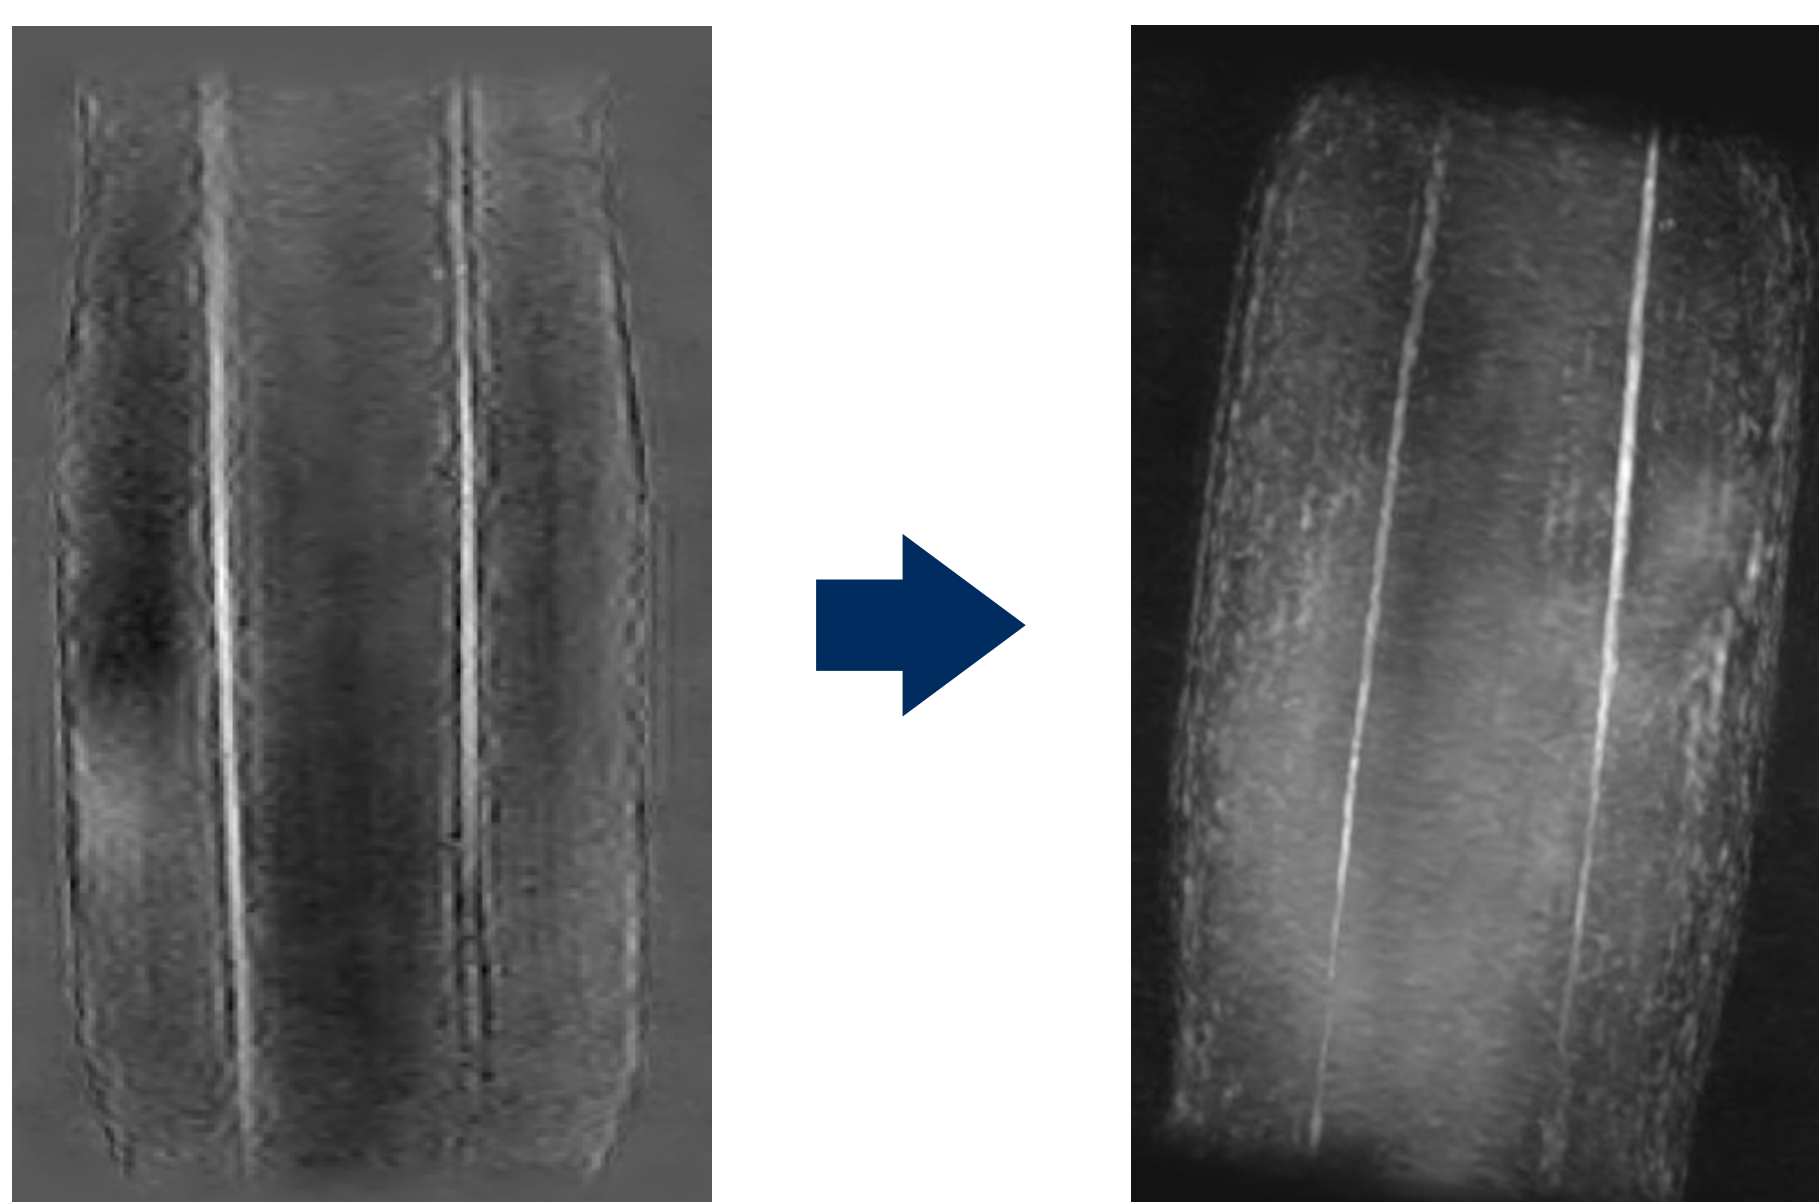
Left: subtraction of the MRI flow scan without SPIO (60 µm Fe) from the scan with SPIO contrast. Right: 3D maximum intensity projection (MIP) of the resulting subtracted image.
